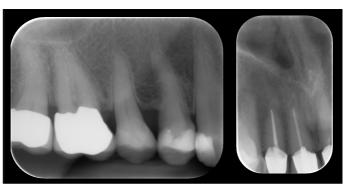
Preoperative radiograph of teeth 14-17.
